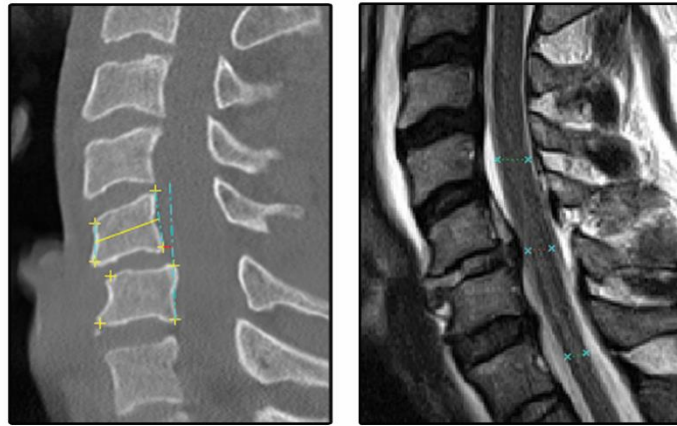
Forty-one year old male sustained a C5/C6 unilateral facet fracture-dislocation (DFI Stage 2) without neurological deficit following a motor vehicle accident. Mid-sagittal computed tomography (CT) scans (left) demonstrated 13% vertebral translation at C5/C6. No signal change, and 8% spinal cord compression were identified on T2-weighted magnetic resonance imaging (right).
